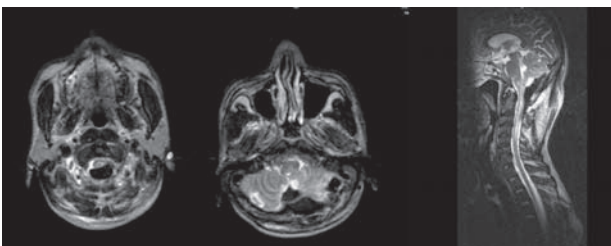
MRI of brain and cervical spine showing hematoma in posterior fossa extending into the cervical extradural space upto C2 level.
